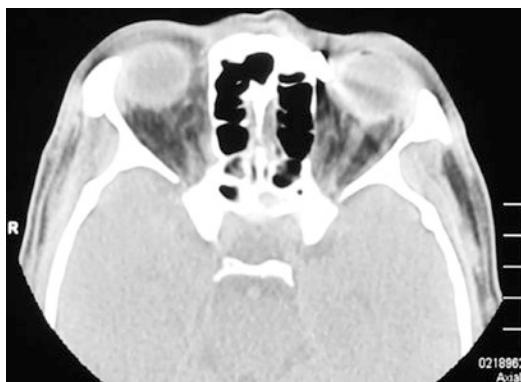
Orbital horizontal CT scan showed that the left orbital margin was adjacent to the high-density metal foreign body shadow
